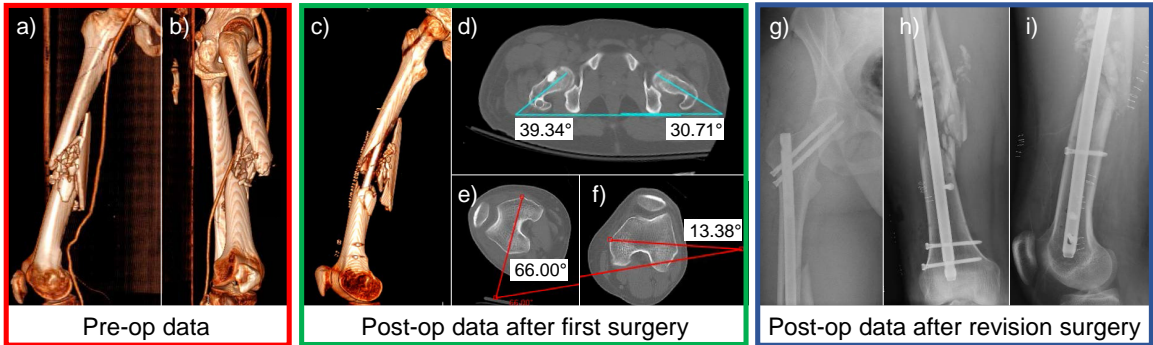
Difficulties arise in addressing rotational alignment in long bone fractures - The 3D preoperative CT scan of the right femur of a patient with a ballistic fracture of the femoral shaft is shown in (a-b). As seen in these images, due to the significant comminution, there are few anatomical cues as to the correct rotational alignment of the bone. (c) shows the postoperative CT of the same femur after reduction and placement of a cephalomedullary nail. The varus/valgus alignment appears to be restored (see Fig. 1.6); however, significant rotational malalignment is present with excessive external rotation of the distal aspect of the femur. Axial cuts from the postoperative CT scan are shown in (d-f). As shown in (d), the hips are in relatively similar position (right hip  $\sim 10^\circ$  externally rotated vs. the left). However, in (e), the operative right knee is over  $40^\circ$  more externally rotated than the healthy contralateral side in (f). Figures (g-i) show the anteroposterior (AP) view of the right hip, AP view of the right femur, and the lateral postoperative radiographs after revision cephalomedullary nailing with correction of the rotational deformity. The revision surgery includes removal and correct replacement of the intramedullary nail.
